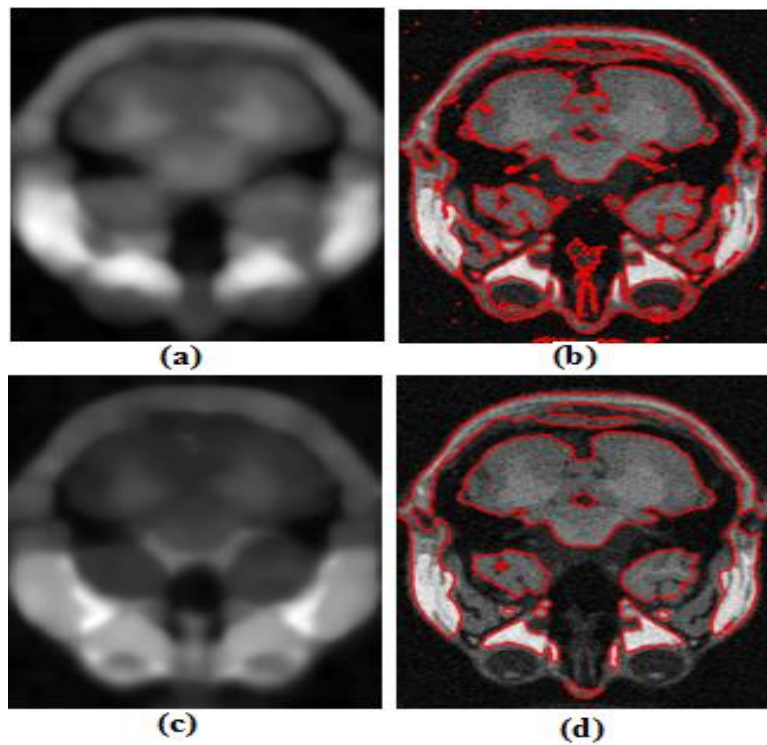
On a noisy MRI image (a, b) Bias field & final contour using C. Li et al method (c, d) Bias field & final contour using proposed method
